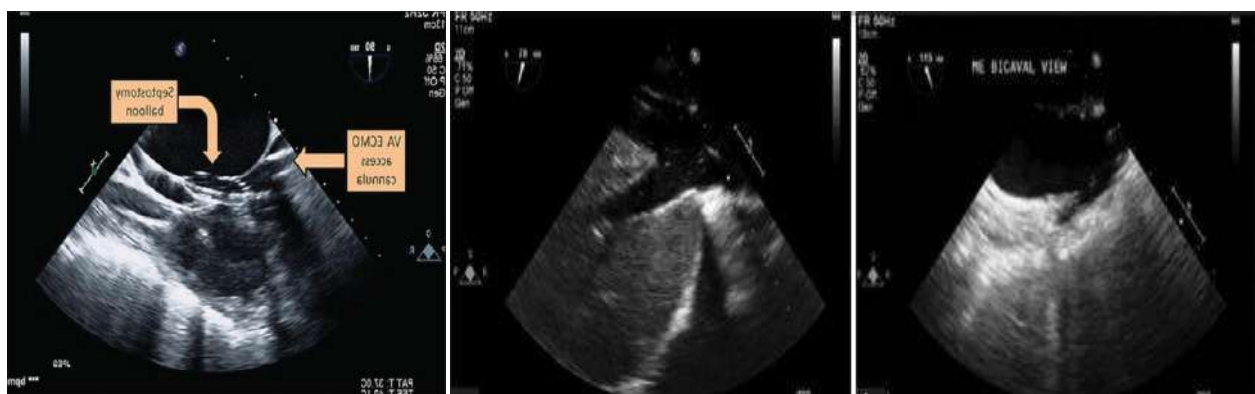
Transesophageal echocardiography is an ideal procedure for guiding the septostomy catheter and balloon inflation.
